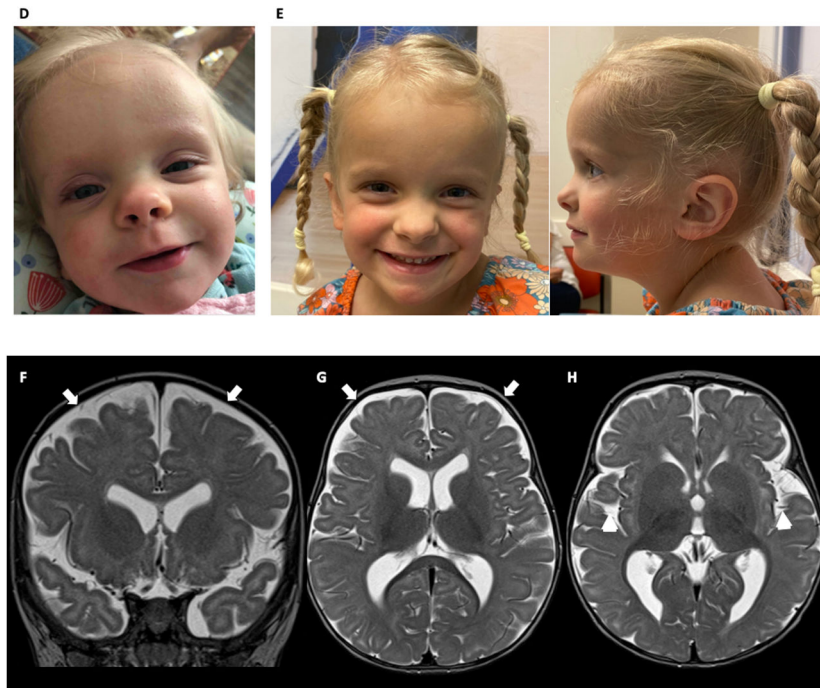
Clinical features of *EEF2*-related neurodevelopmental disorder. (A-C) Facial features and neuroimaging finding of the Patient 1. (A) Patient 1 picture at 19 months. (B) Patient 1 pictures at 5 years. Note prominent forehead, midface hypoplasia, right microphthalmia with ptosis, small palpebral fissures, deeply set eyes, low set ears, small upturned nose, long philtrum and thin upper lip. (C) Brain MRI of the Patient 1 at 3 weeks of age. Mild prominence of the extra axial space is demonstrated. (D-H) Facial features and neuroimaging finding of the Patient 2. (D) Patient 2 pictures at different ages, 15 months, and (E) 4 years, show the evolution of facial appearance and dysmorphisms. (F-H) Brain MRI findings of the Patient 2 at 8 months old. There is prominence of the extra-axial subarachnoid CSF spaces in the frontoparietal regions (arrows, F and G), along with prominence of the lateral ventricles and under-opercularization of the insula bilaterally (arrows, H).
